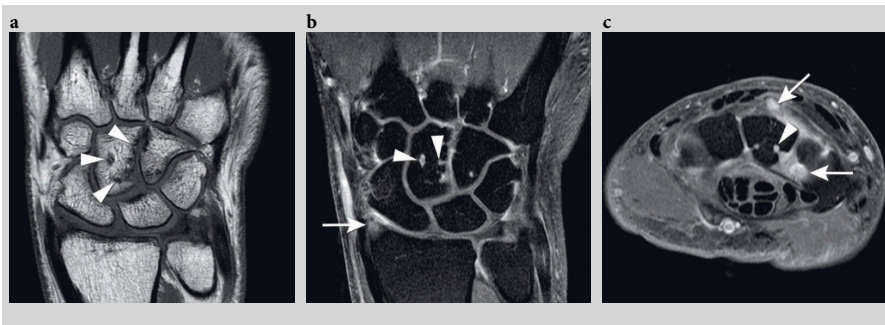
Magnetic resonance images (MRIs) of the right wrist in a patient with undifferentiated arthritis and erosions. Coronal T1 TSE (a), coronal (b) and axial (c) T1 TSE fat saturation (fatsat) with gadolinium. The multiple cortical defects are seen on coronal T1 TSE, enhancing on coronal and axial T1 TSE fatsat with gadolinium (arrow heads). Unsharply defined intraosseous enhancement is also present in the radial styloid (arrow), consistent with edema (b). Enhancing synovium is appreciated on the axial image intercarpal and at the dorsal side of the carpus (c; arrows).
